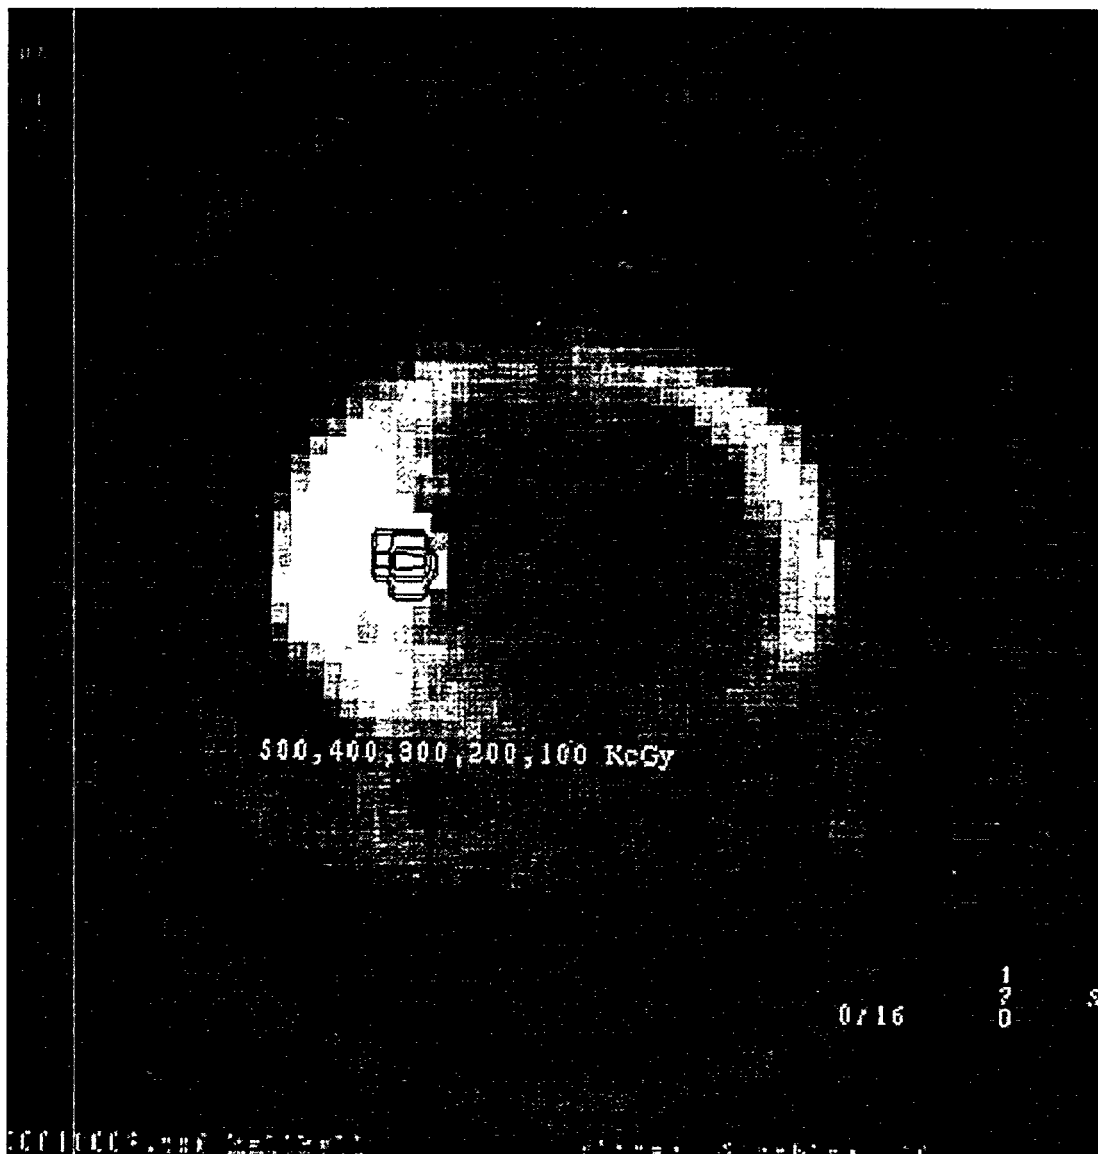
Isodose distribution displayed on a transaxial SPECT slice and generated from bremsstrahlung SPECT imaging of P-32 from a patient with cancer of the pancreas. The isodose lines shown are 5, 4, 3, 2, and 1 kGy.
